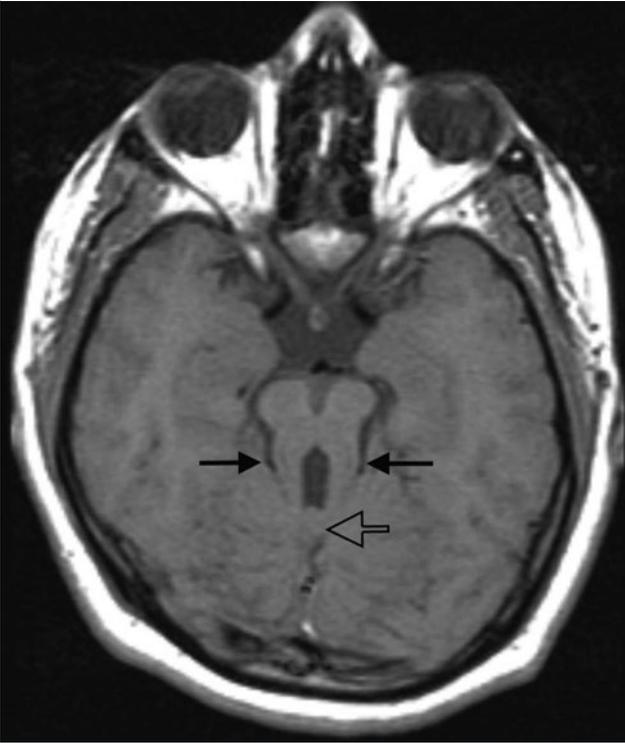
Axial T1-weighted magnetic resonance image through the midbrain of a patient with Joubert syndrome. The deep interpeduncular fossa, thick superior cerebellar peduncles (*arrows*), and hypoplastic vermis (*open arrow*) together give the appearance of a molar tooth.
